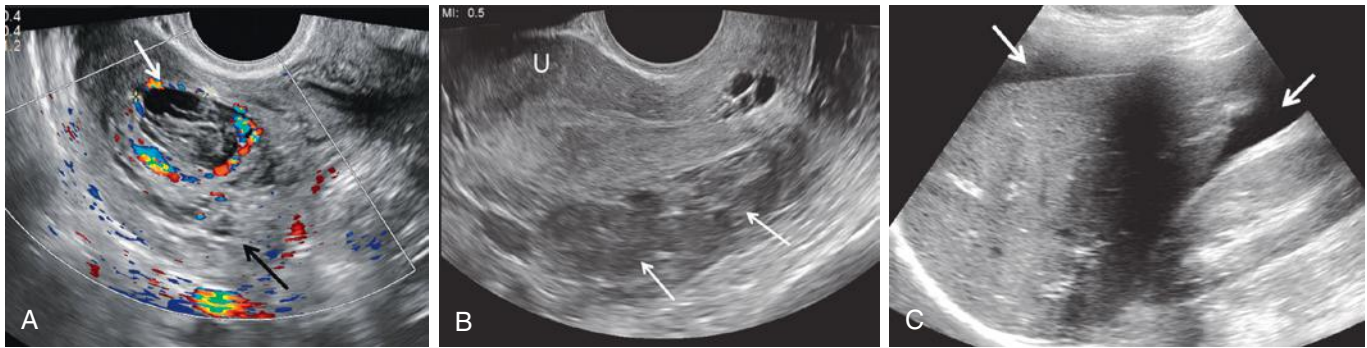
Ruptured hemorrhagic ovarian cyst. A, Color Doppler sonographic image demonstrating the “ring of fire” appearance of a hemorrhagic corpus luteum (*white arrow* and *calipers*), which is still recognized despite rupture. The ovary is not identified as a discrete structure as it is surrounded by complex material of mixed echogenicity compatible with blood clot (*black arrow*). B, Large amount of complex fluid containing echoes (*arrows*) compatible with blood in the cul-de-sac posterior to the uterus (U). C, Large amount of hemoperitoneum (*arrows*) in the upper abdomen adjacent to the liver and in the Morison pouch.
